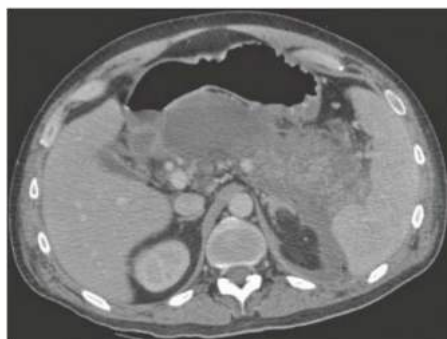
• Acute necrotizing pancreatitis in a patient admitted 1 week ago now with persistent fevers and leukocytosis. CT reveals lack of contrast enhancement in most of the body and tail of the pancreas without encapsulation.
